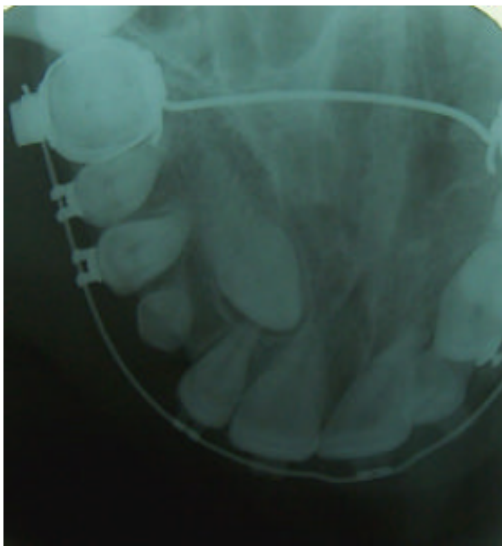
Occlusal x-ray revealed the palatal impaction of the tooth
